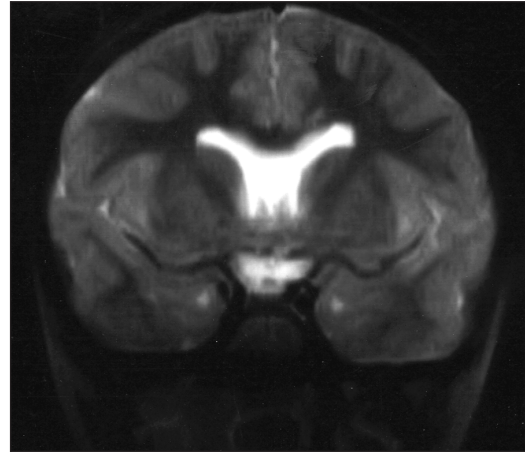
Early stage follow-up T2-weighted magnetic resonance image of the patient after the second operation.
